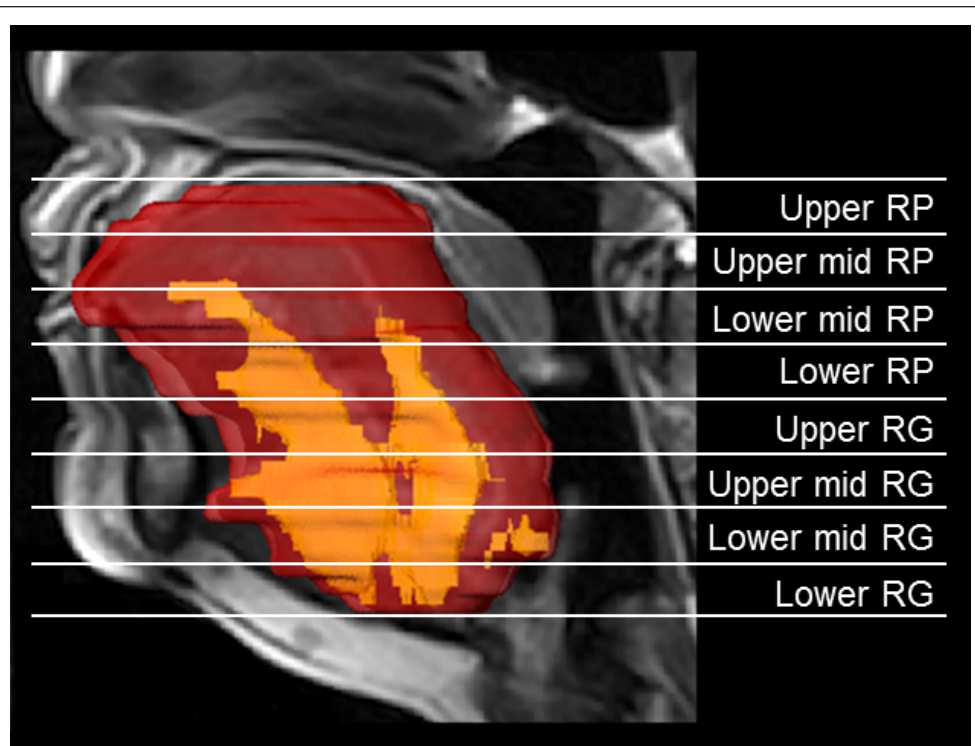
Representative three-dimensional volumetric reconstruction of tongue (red) and fat within tongue (yellow) from series of 3-mm contiguous axial MR images superimposed on a midsagittal image; 8 sections of apneic tongue (red) including tongue fat (yellow), 4 within RP (retropalatal) region and 4 within RG (retroglottal) region of tongue. There is substantially more fat at base of tongue.
